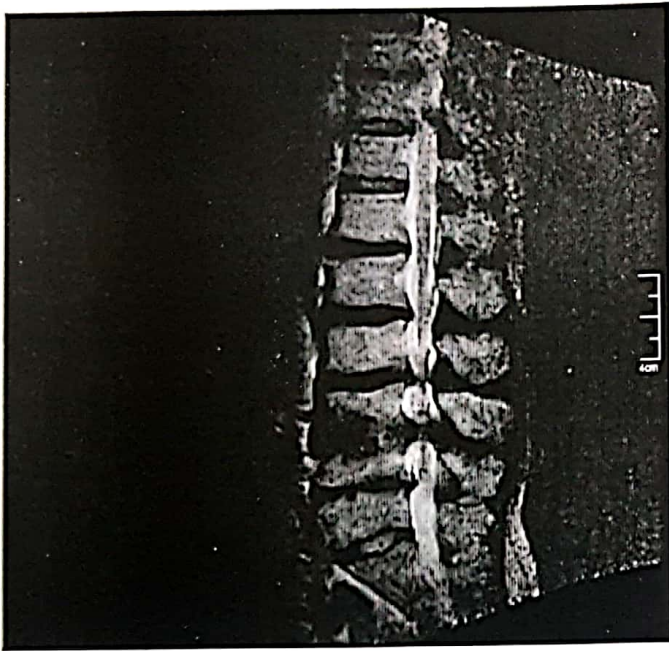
Sagittal Magnetic Resonance Imaging of the lumbar region showing multiple level disc prolapse with spondylotic changes.
